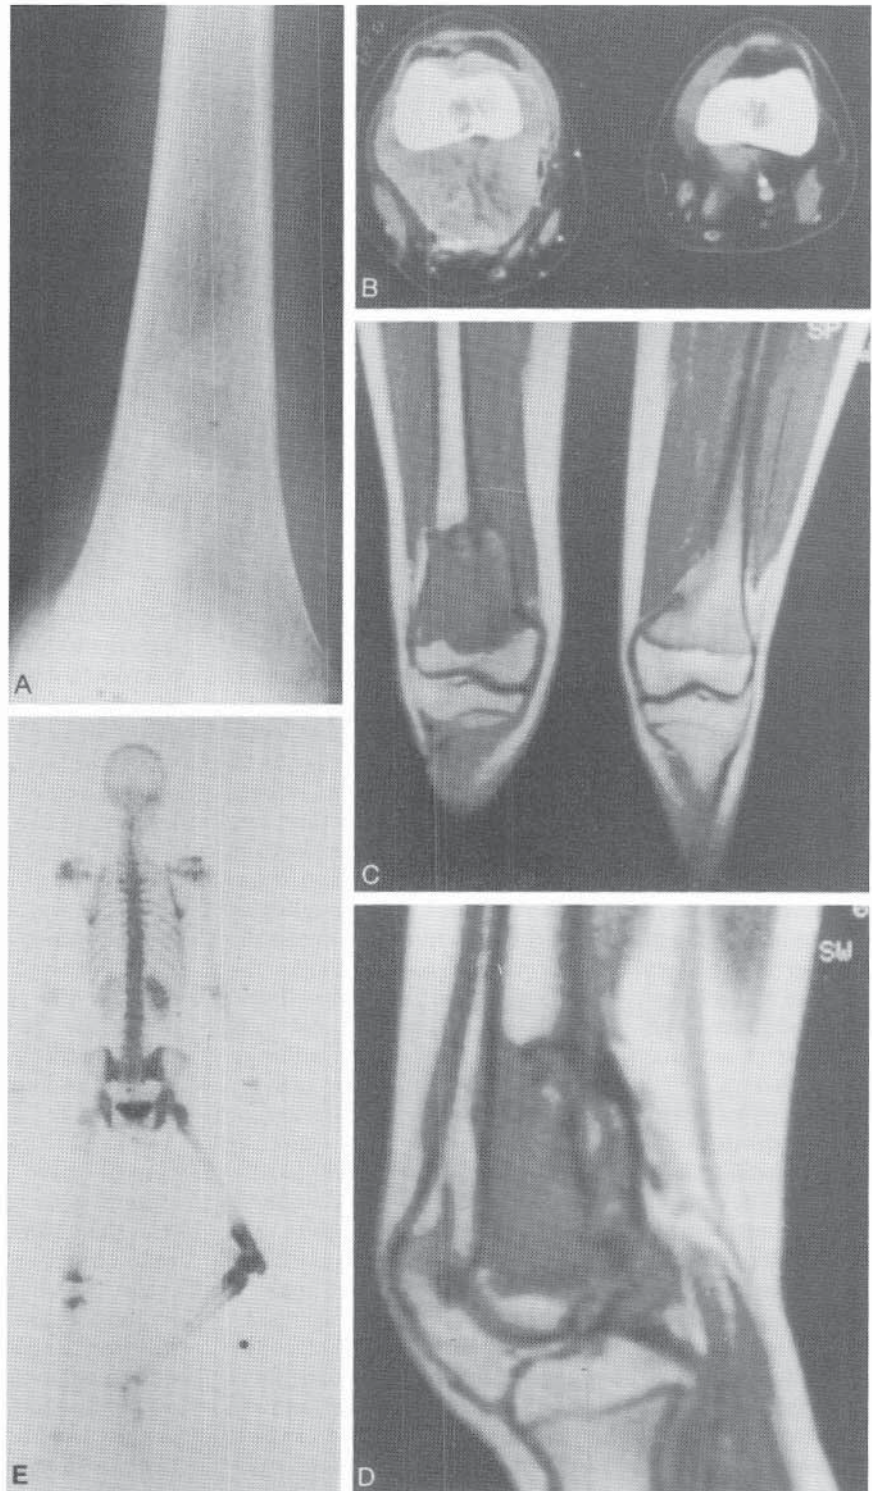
Osteogenic sarcoma of the left distal femur. A, Plain AP radiograph. Note the distal metaphyseal and lower diaphyseal sclerotic lesion. B, CT scan showing bone-forming tumor. C and D, MR images showing the extent of the tumor and its relationship to the popliteal soft tissue. E, Bone scan with technetium 99m showing increased uptake in the distal femoral metaphyseal region.
